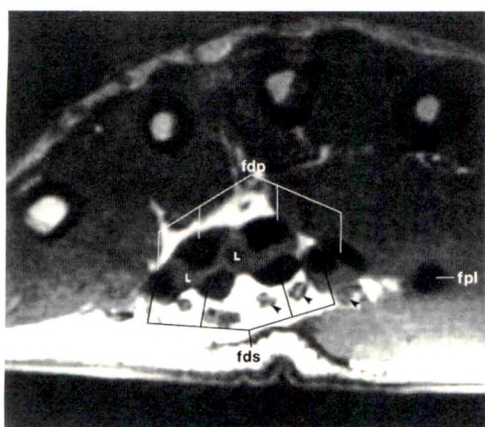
Axial MR image (TR 600, TE 25) at level of proximal metacarpals. Right wrist viewed toward elbow with palm down. Note three terminal divisions of median nerve (arrowheads) and origin of lumbrical muscles. (See key for abbreviations.)
